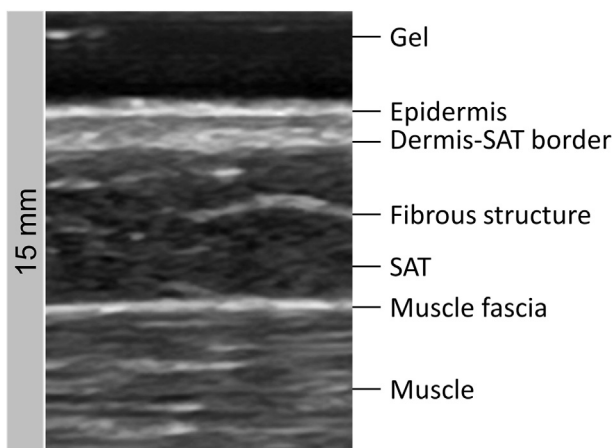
Example of a typical ultrasound image. Ultrasound site: brachioradialis; subcutaneous adipose tissue (SAT) layers can be detected uncompressed due to the application of a thick gel layer between the probe and the skin. The upper and lower borders of SAT (dermis and muscle fascia, respectively) are clearly visible. The area in-between represents the SAT layer. Embedded fibrous structures are also visible. SAT thicknesses were calculated via the semiautomatic image segmentation software. Speed of sound in fat: $c = 1450$ m/s. SAT, subcutaneous adipose tissue.
